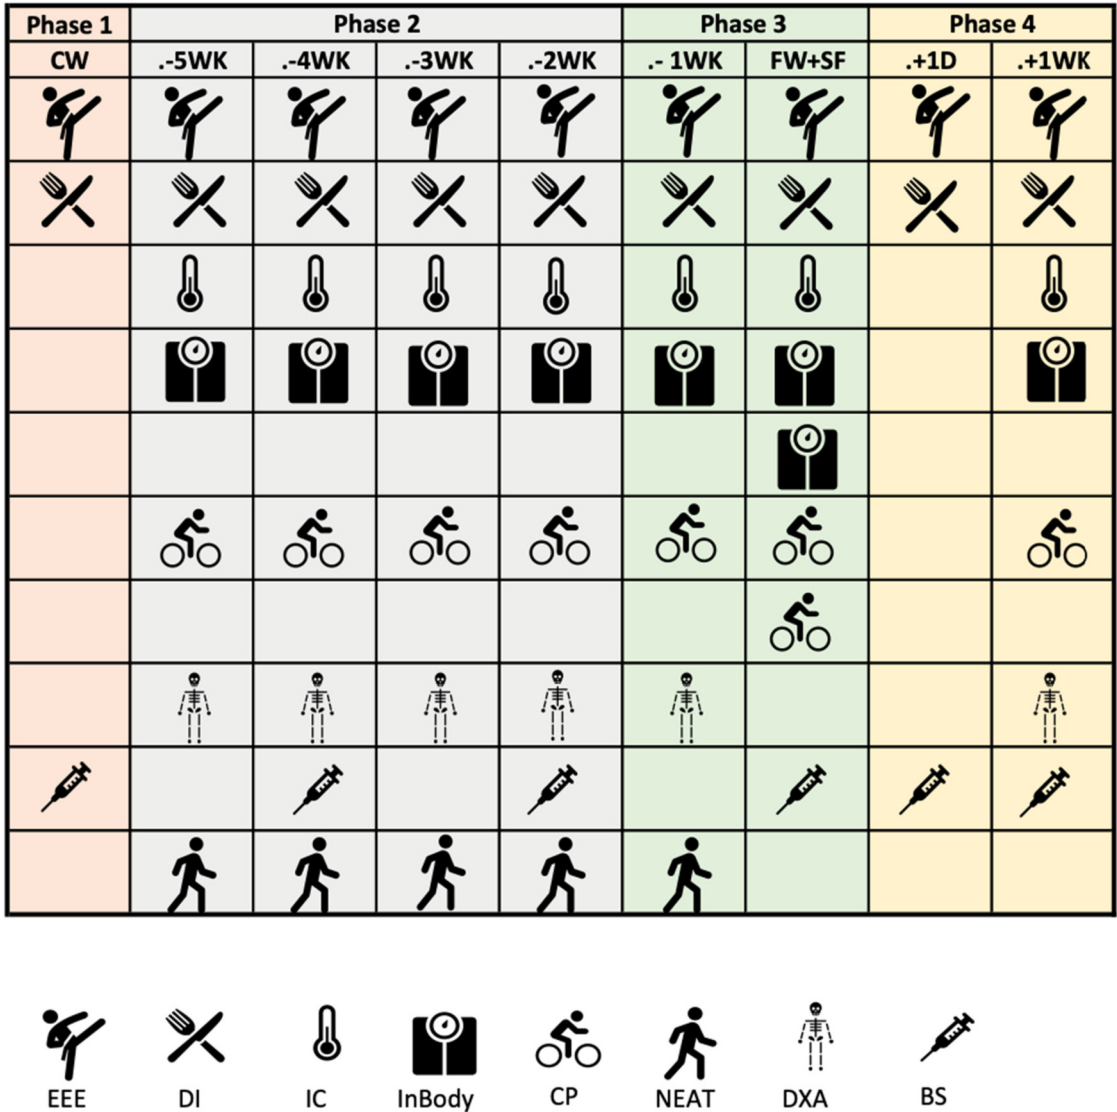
Instruments and parameters measured during the intervention. EEE, exercise energy expenditure; DI, dietary intake; IC, indirect calorimetry; CP, critical power test; NEAT, non-exercise energy expenditure; DXA - by dual-energy x-ray absorptiometry and BS, blood samples.
